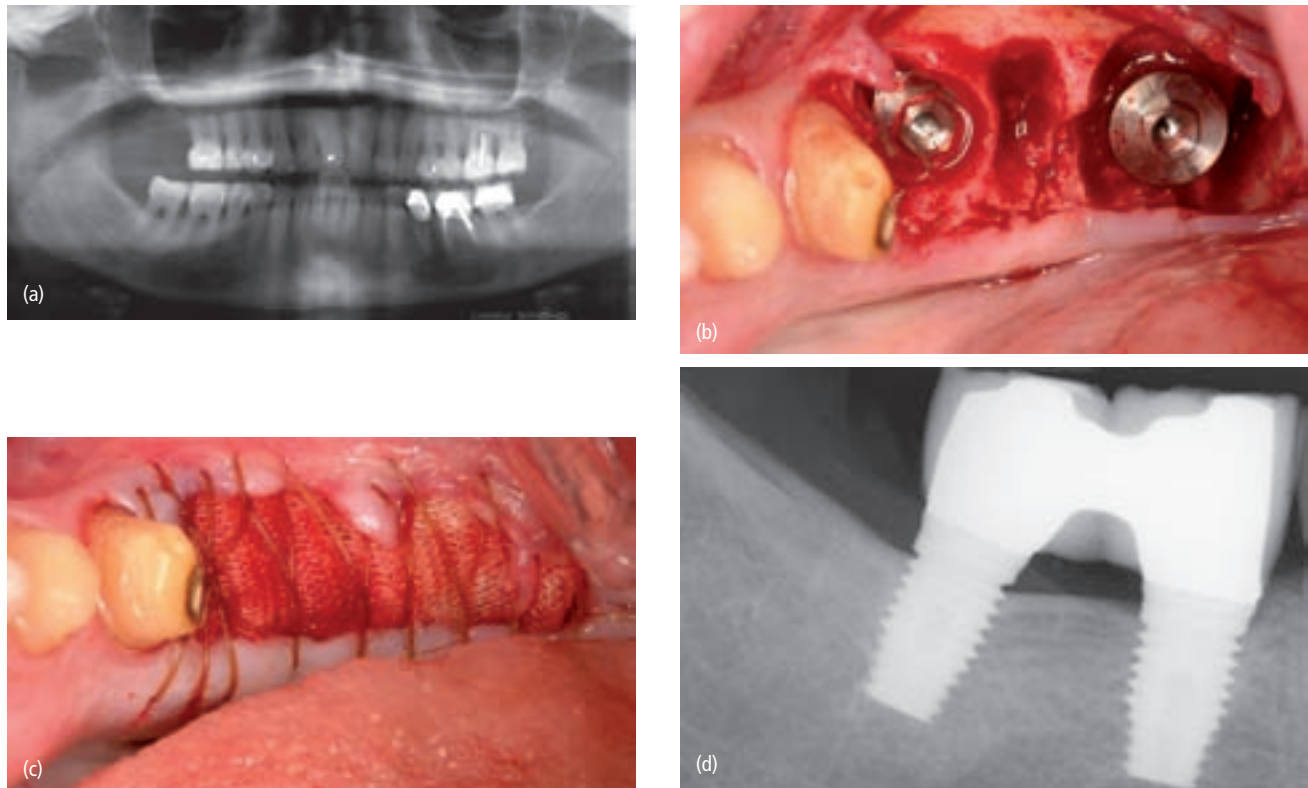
(a) The mandibular right molars were hopeless and required removal. (b) Implants were placed into the existing sockets. Note the spaces around the implants which required bone grafting. (c) After firmly packing a mineralized allograft around the implants and into the sockets, a PG910 membrane was placed. No attempt was made to obtain primary closure of the tissues. (d) A radiograph taken 5 years after restoration demonstrated crestal stability.
